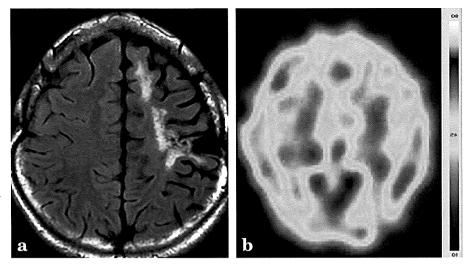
Pre-operative images: a) MRI (FLAIR) showing cerebral infarction on the left MCA and ACA territory and b) SPECT showing low cerebral blood flow in bilateral cerebral hemisphere mainly on the left MCA region.
